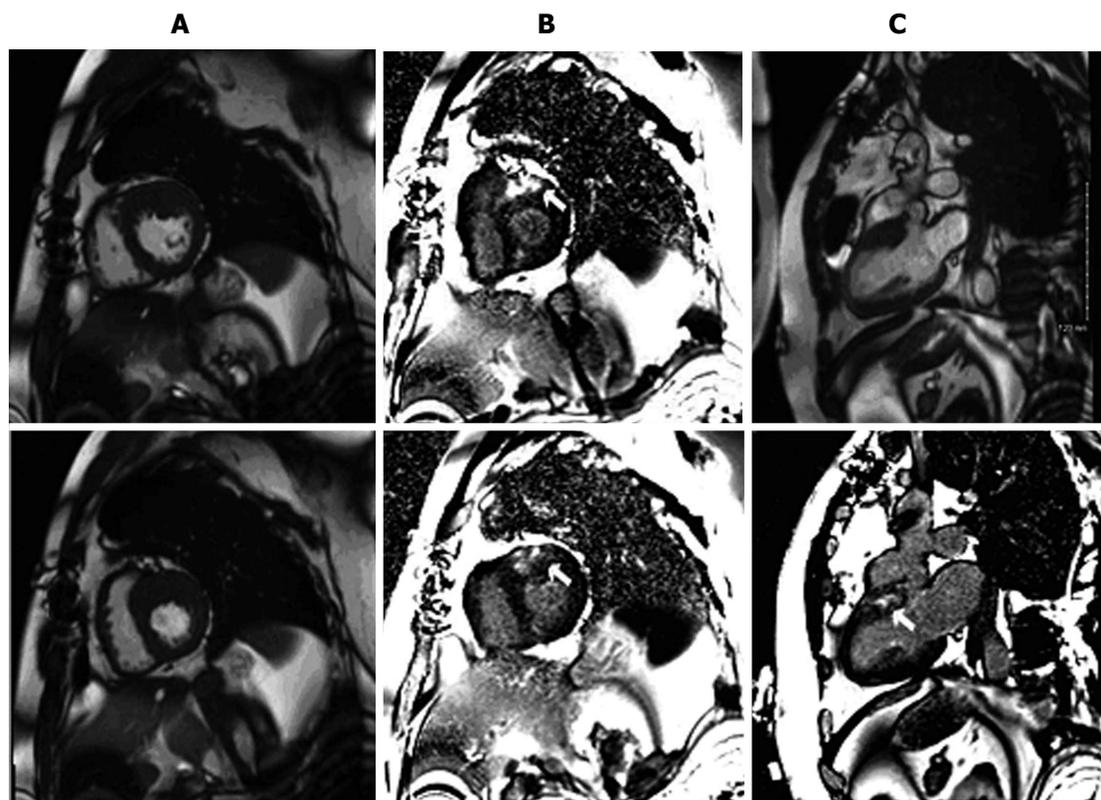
Basal anterior hypertrophic cardiomyopathy in a 45-year-old man with a history of syncope. Cardiac magnetic resonance imaging demonstrated severe thickening of basal anterior wall with a maximal measurement of 25 mm. A: Two chamber short-axis cine images; B: Late delayed gadolinium enhanced images; C: Two chamber long-axis cine images (top panel). Late delayed gadolinium enhanced images (bottom panel). Patchy, non-coronary artery disease scarring in the hypertrophied areas is indicated by white arrows.
